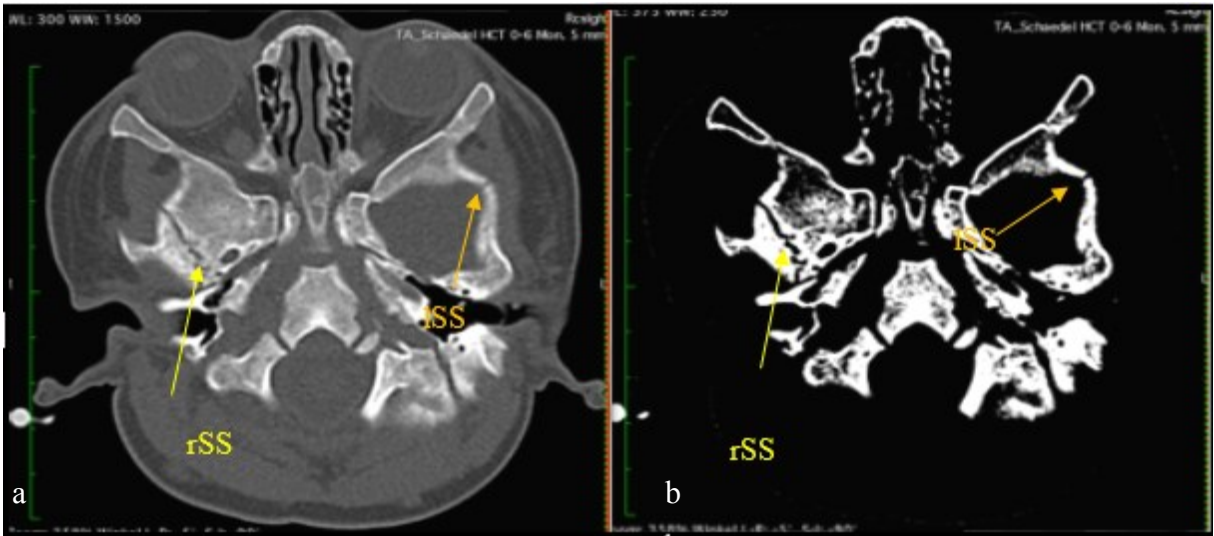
CT image of a pediatric skull of a 3 months old male in axial view in a bone window and b manual WW/WL settings (yellow arrow: middle and posterior part of right sphenosquamous suture, orange arrow: anterior part of left sphenosquamous suture).
